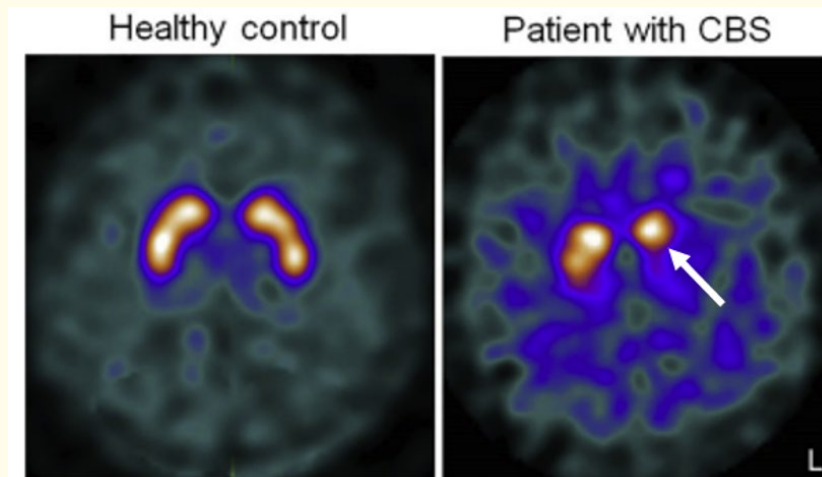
DAT SPECT study of a healthy control patient (left) and a patient with CBD (right). The CBD patient shows reduced DAT uptake, bilaterally and asymmetrically in the putamen, with lower uptake in the left cerebral hemisphere (white arrow) [6].
